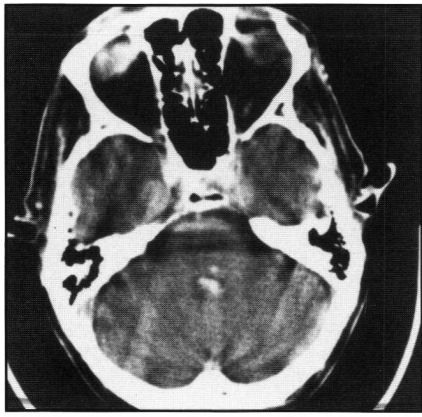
This CT scan of patient 2, without contrast, at the level of the medulla shows a small hyperdensity with the medullary parenchyma and the fourth ventricle. Repeat CT scan two weeks later showed complete resolution of the hematoma.
